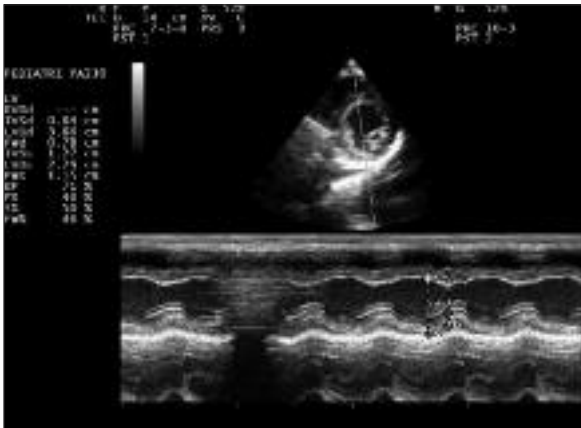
The echocardiographic examination which is made one week after the electric shock.
